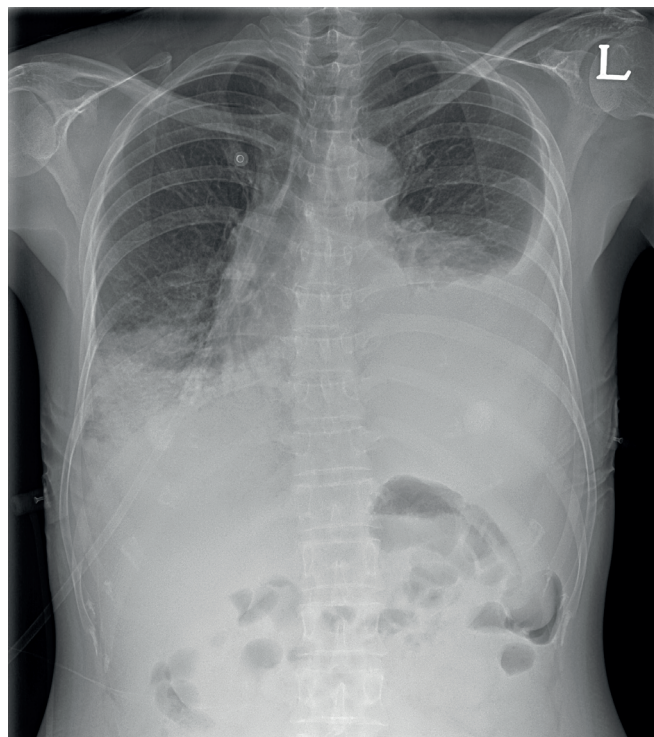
Initial chest radiography revealed pleural effusions in both lung fields, which were more severe on the left side.
